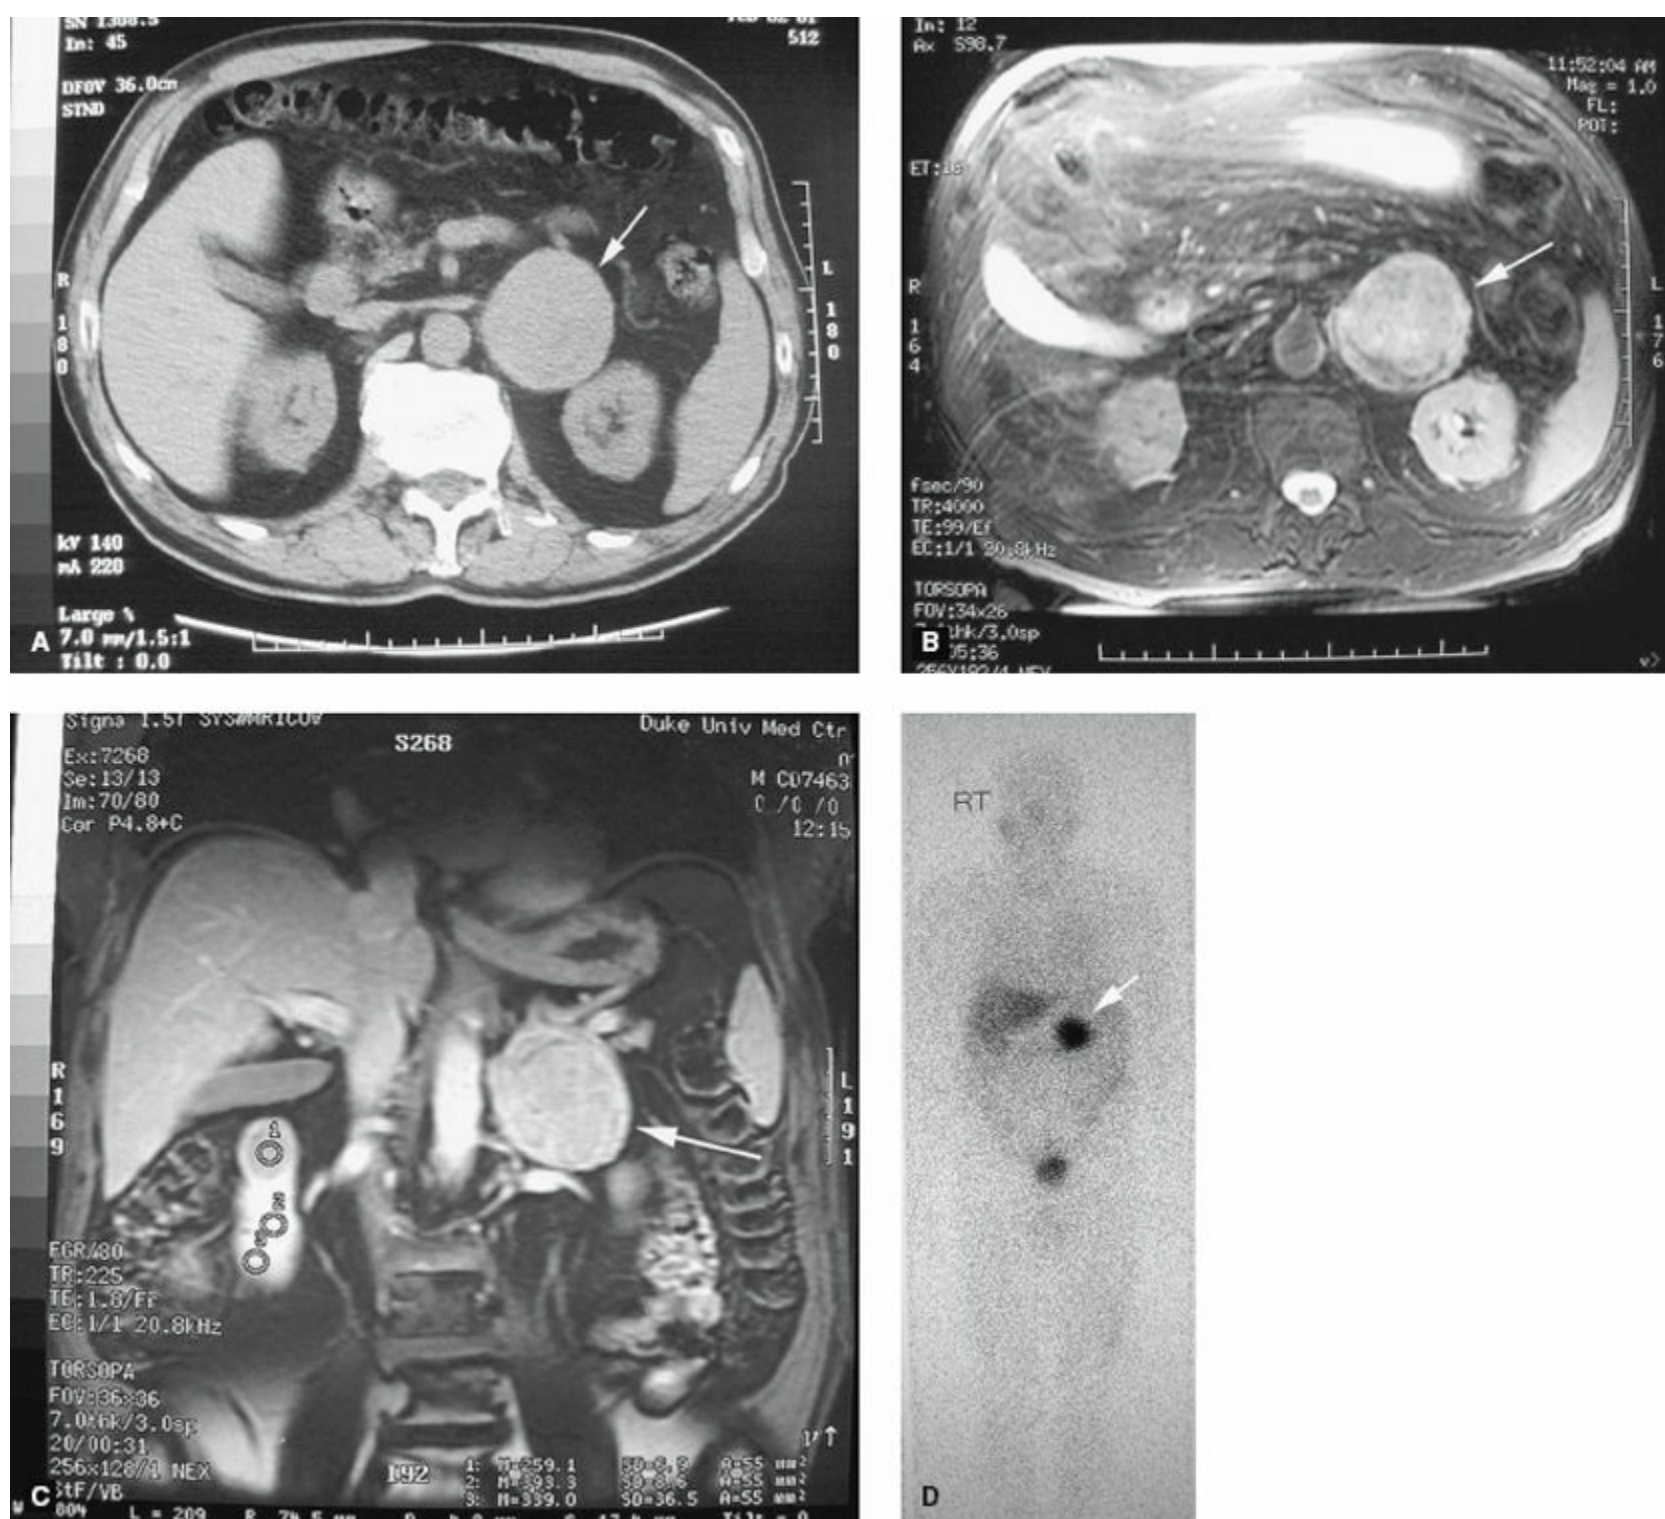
Imaging of pheochromocytoma (arrows). A: Computed tomography scan shows well-circumscribed left adrenal mass. B: T2-weighted magnetic resonance imaging shows the mass to be heterogeneously bright, consistent with pheochromocytoma. C,D: Coronal contrast enhanced MRI and near-simultaneous ^{131}I -metaiodobenzylguanidine (^{131}I -MIBG) scanning show location of the pheochromocytoma and relationship to surrounding structures.
